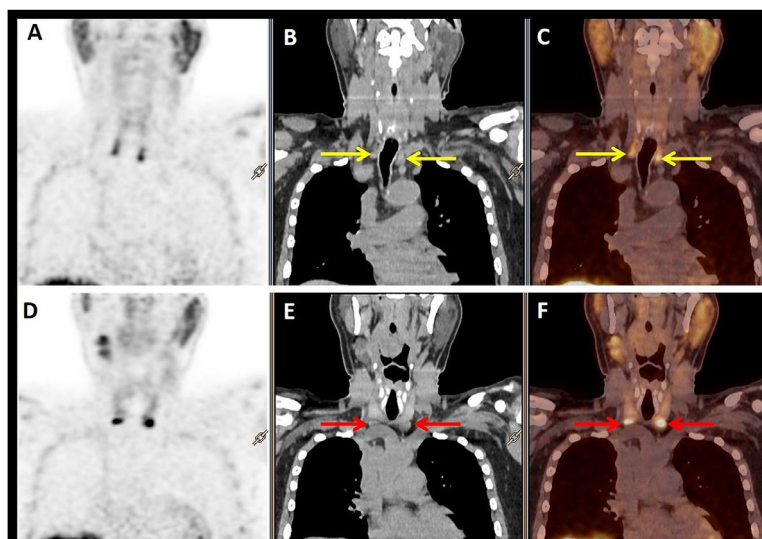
Patient on hemodialysis for 18 years, with serum parathyroid hormone level 2090 ng/L. FCH PET/CT was performed and showed four hyperfunctioning parathyroid glands with uneven FCH uptake: right superior (RP4) SUVmax 7.6, right inferior (RP3) SUVmax 14.3, left superior (LP4) SUVmax 8.5 and left inferior (LP3) SUVmax 14.4. Superior (P4) and inferior (P3) parathyroid glands may be located at the same level in the neck, with P4 located posteriorly to P3 due to embryonic development, which highlights the importance for tomographic imaging for correct localization of HFPTG.
